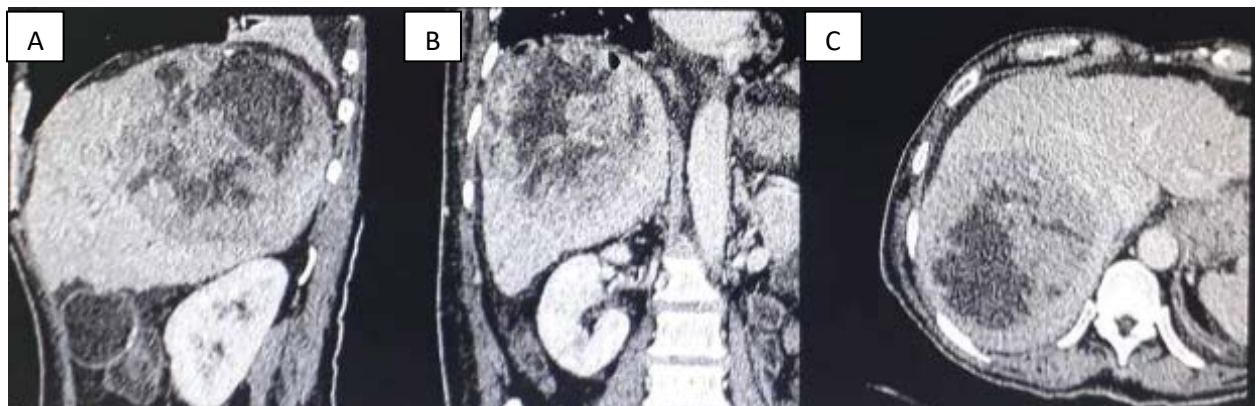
Contrast-enhanced Whole Abdominal CT scan in the portal venous phase (A to C): Sagittal (A), Coronal (B) and Axial (C) reconstruction of the heterogeneously enhancing mass almost encompassing the entire right lobe with central area of necrosis and intralésional air pockets.
